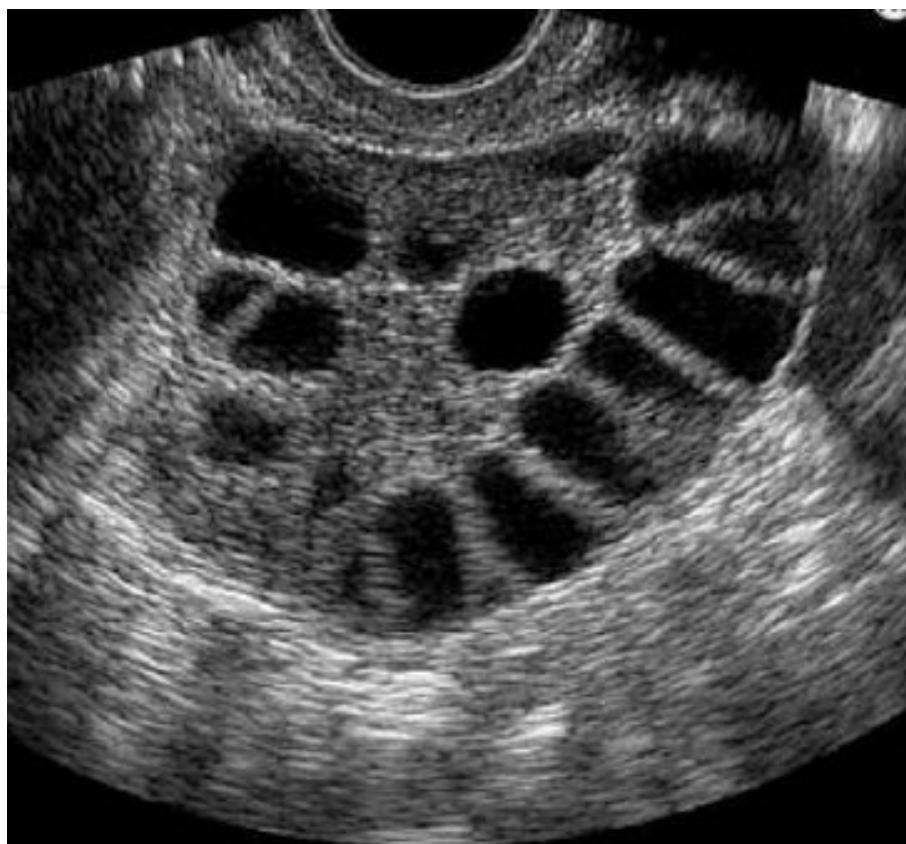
Ultrasound image of an ovary with PCOD
